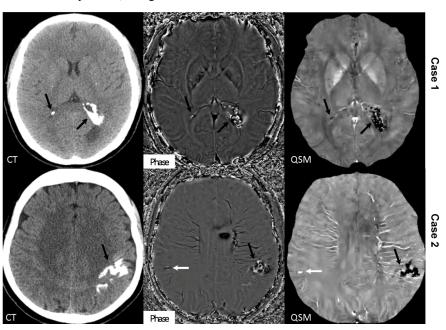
Typical calcifications (black arrows) showed negative on QSM, hyperintense on CT, heterogeneous but mostly positive on GRE phase images. A paramagnetic lesion suspected as a microbleed (white arrows) shows positive on QSM, negative on GRE phase, isointense on CT images.
